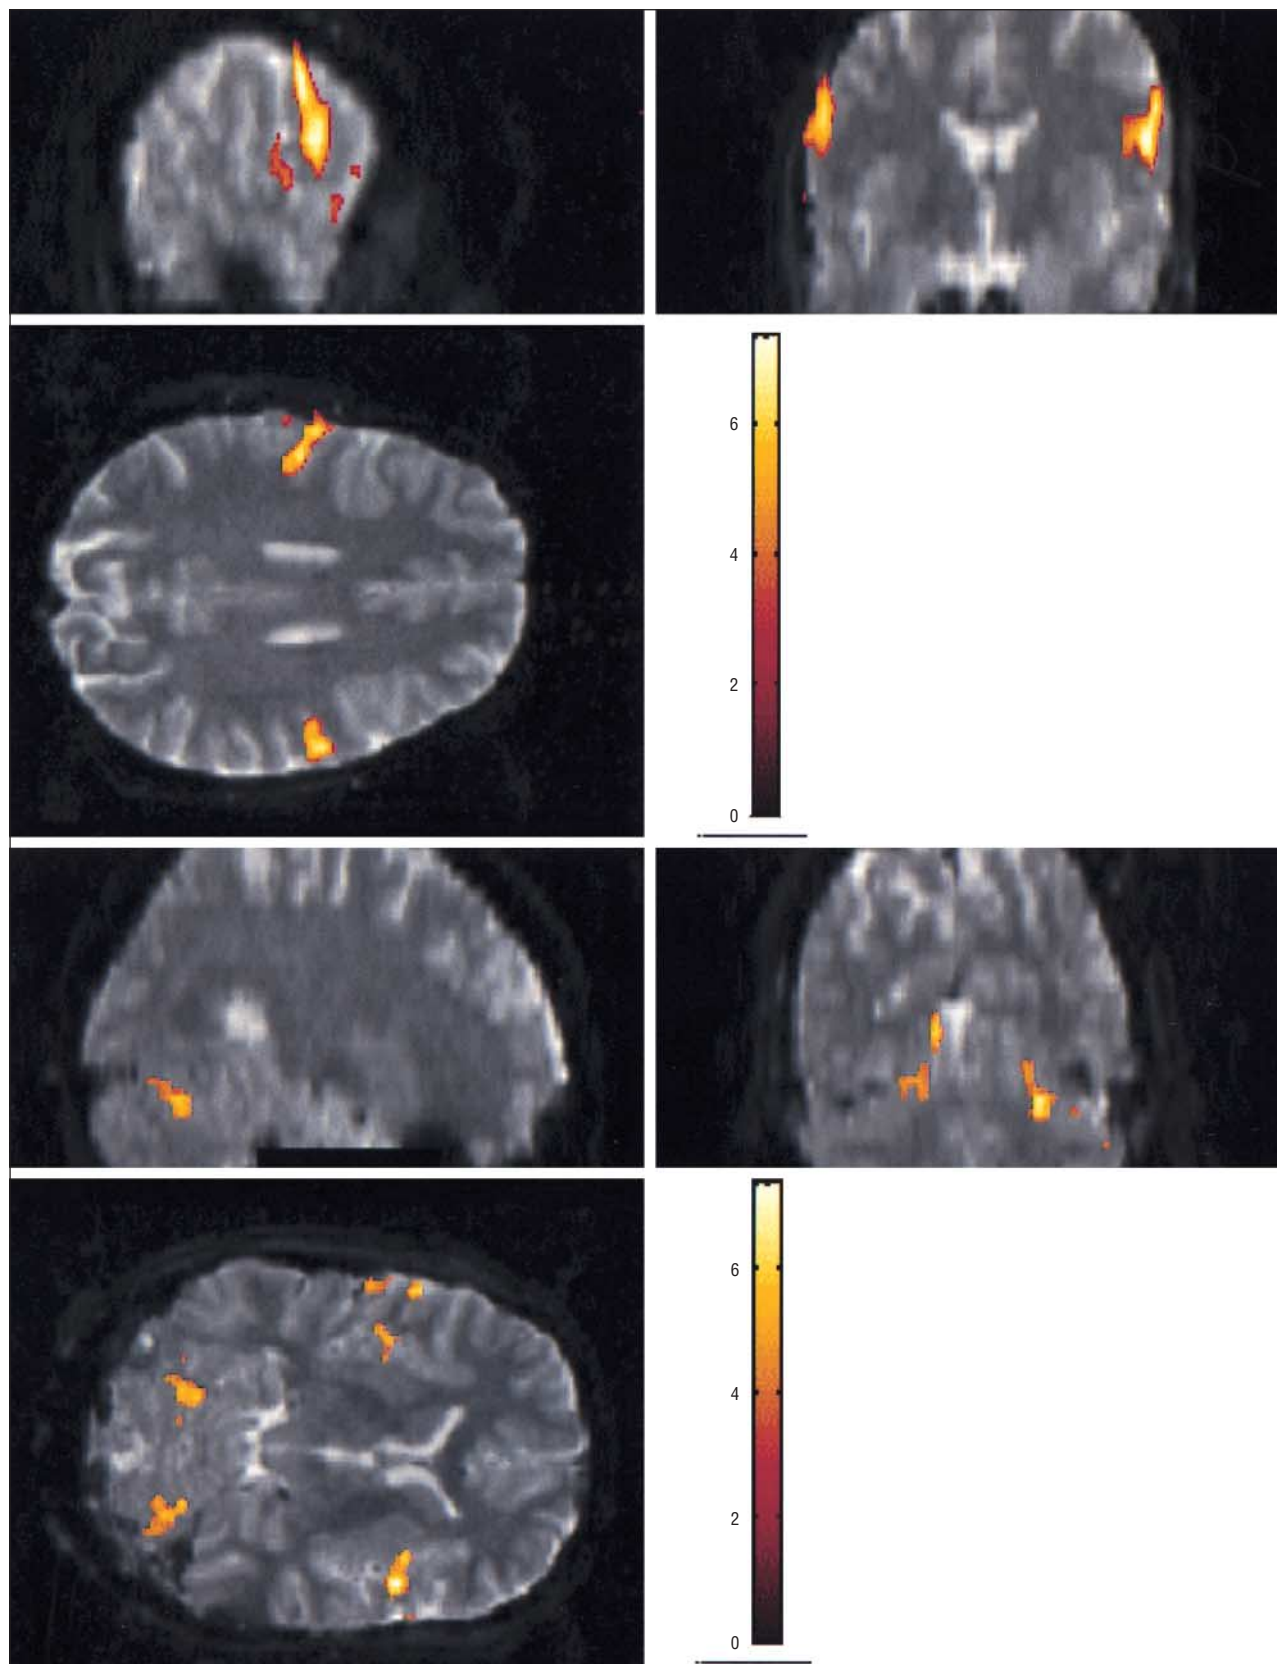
Functional magnetic resonance image during repetitive silent vertical tongue movements of a representative patient.
